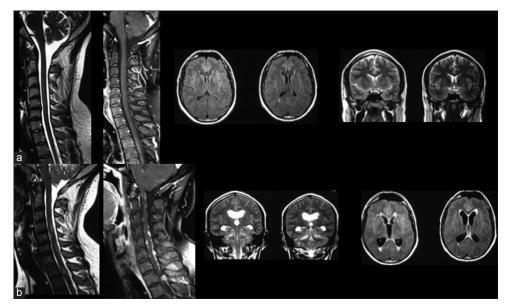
The brain and cervical spine magnetic resonance imaging were normal at the first investigation (a). After 7 months sagittal TI-weighted contrast-enhanced magnetic resonance imaging of brain and spine demonstrated a hypertensive hydrocephalus, leptomeningeal enhancement, and contrast-enhanced masses throughout the cervicothoracic spinal cord surfaces (b)
